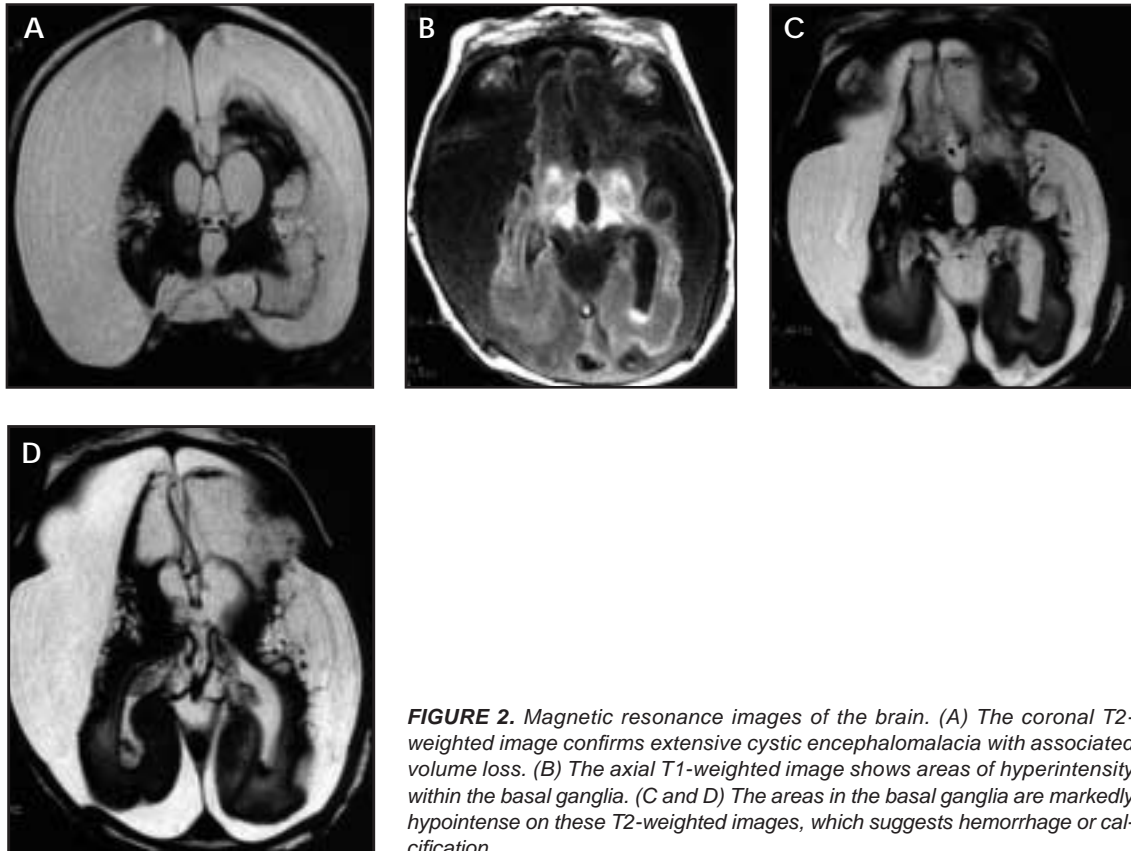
Magnetic resonance images of the brain. (A) The coronal T2-weighted image confirms extensive cystic encephalomalacia with associated volume loss. (B) The axial T1-weighted image shows areas of hyperintensity within the basal ganglia. (C and D) The areas in the basal ganglia are markedly hypointense on these T2-weighted images, which suggests hemorrhage or calcification.
